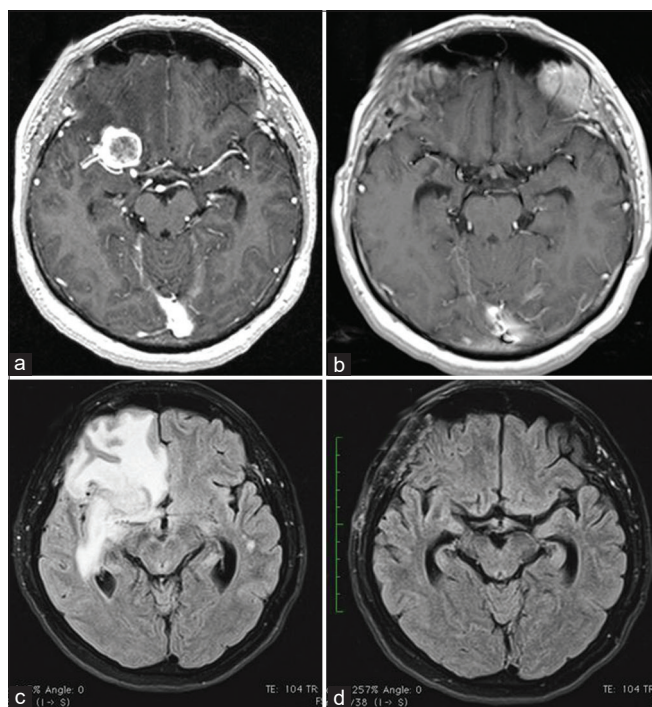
Right clinoid meningioma. MRI T1 contrast-enhanced images before (a) and after (b) surgery showing complete removal of the meningioma. MRI flair images highlight peritumoral brain edema before surgery (c) and at 2 months after surgery (d); an almost complete resolution is clear.
